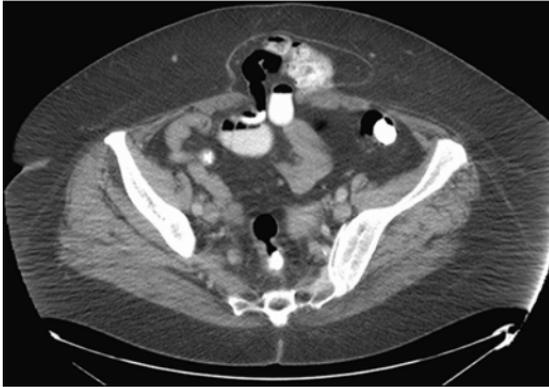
CT scan image of a patient with an incisional hernia through a prior midline incision
